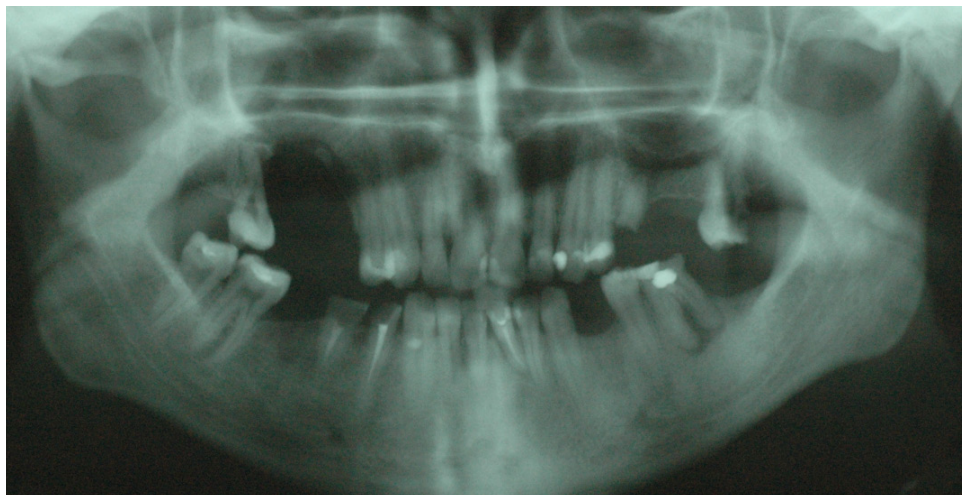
Panoramic radiograph 5 years after operation
